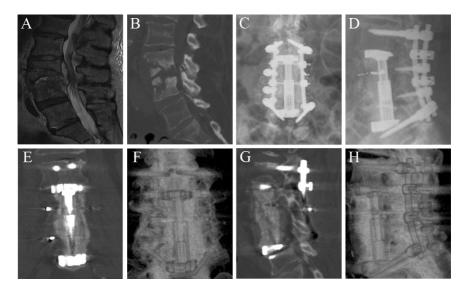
75-year old female suffered from severe back pain. Spondylodiscitis was verified on MRI. She had received broad antibiotics for more than two years. *Mycobacterium tuberculosis* was identified by PCR from pus that was drained from the psoas abscesses during surgery. Antibiotic treatment was then directed towards this pathogen.
